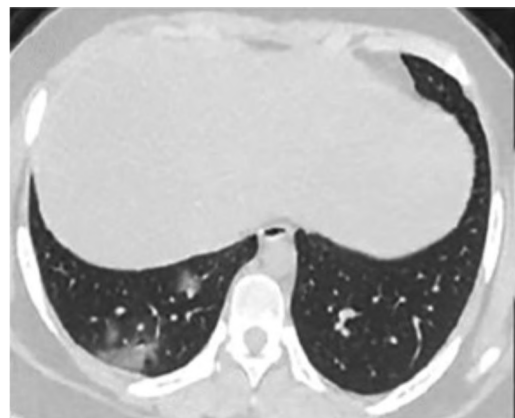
CT scan of a mildly symptomatic child showing a peripheral ground glass opacity.
